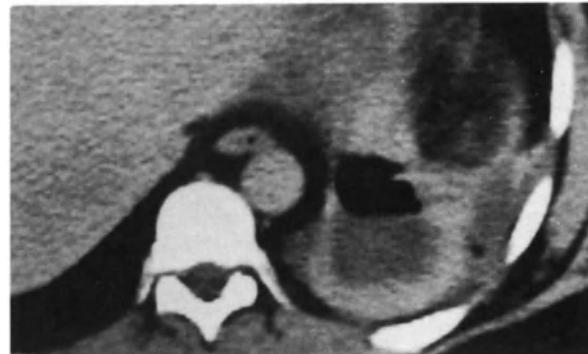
CT scan. Left subphrenic abscess with air fluid level.
